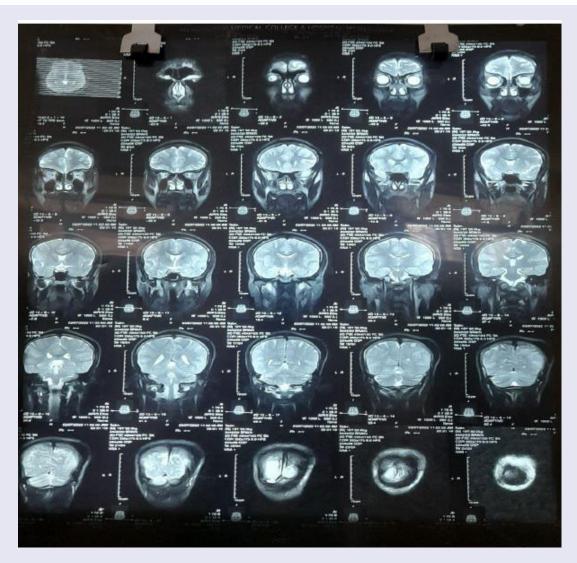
MRI Flim Showing Subependymal Nodule.
